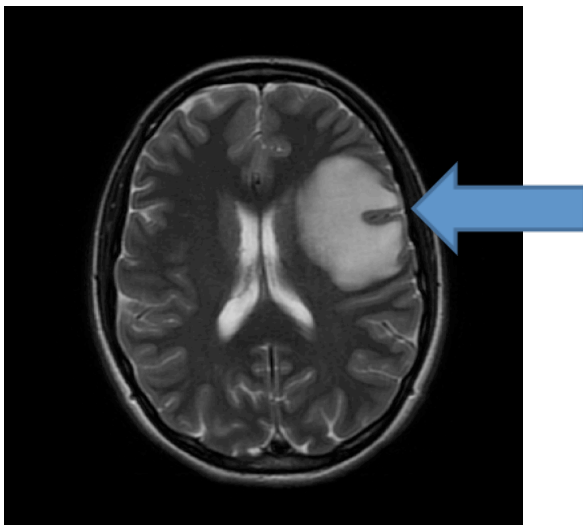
T2-weighted transverse MRI with contrast that highlights the area of vasogenic edema (arrow) and also further demonstrates the midline shift seen in previous images.
